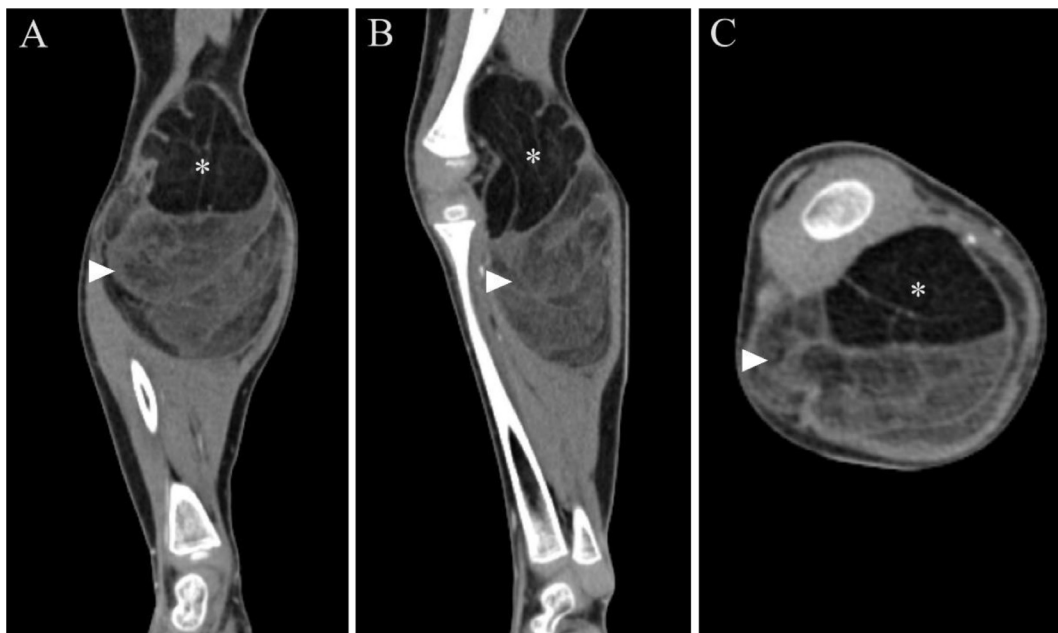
(A) Coronal, (B) sagittal, and (C) axial sections of contrast-enhanced CT scan of the right leg revealed a huge mass from popliteal to proximal cruris areas. The mass was multilobulated with mixed fat (asterisk) and solid soft tissue (arrow head) components.
